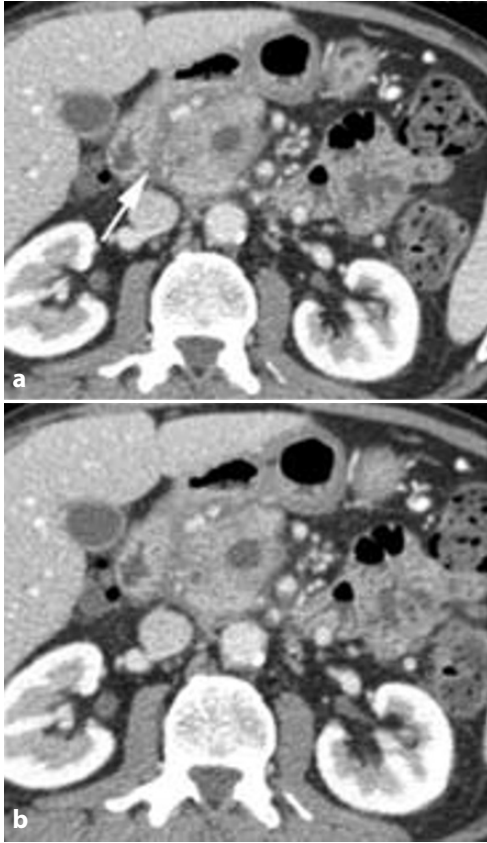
Thickening of the duodenal wall in the groove region, with a hypovascularized appearance (*arrow*) at CT (a, b). In the pancreatic head, a small pseudocystic lesion is also visible
